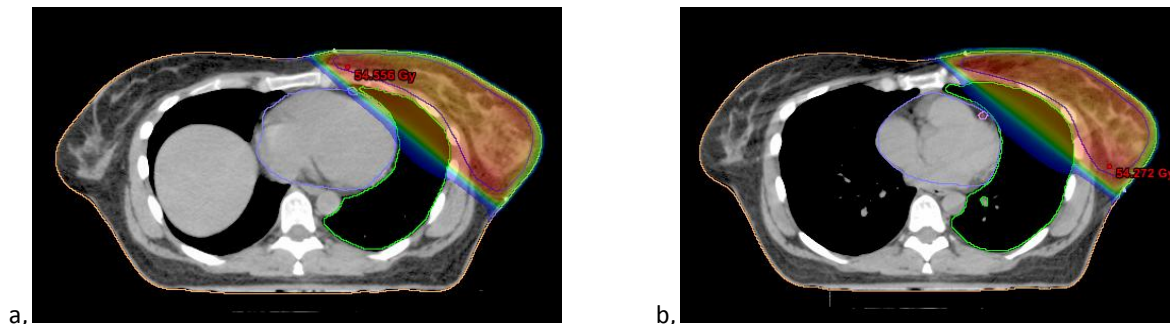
Dose distributions in the same transversal CT-slice for conventional treatment (a) and respiratory gating (b)
